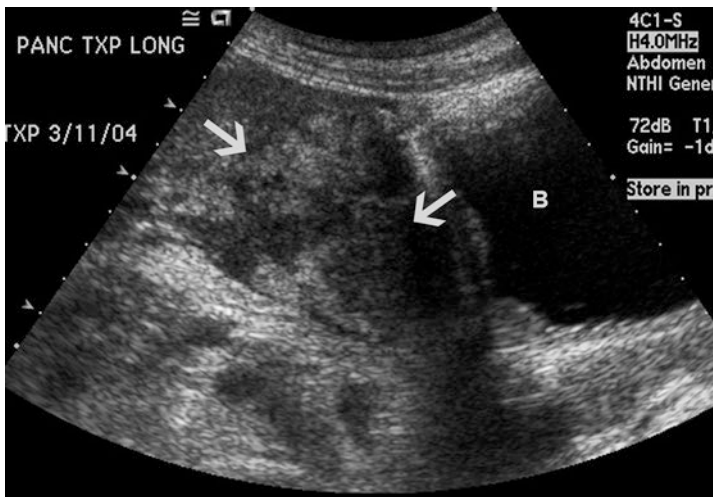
Sagittal ultrasound image of the pelvis showing inhomogeneous echotexture of the pancreas transplant (arrows) due to acute pancreatitis. Distended bladder (B) may help visualization of the transplant
